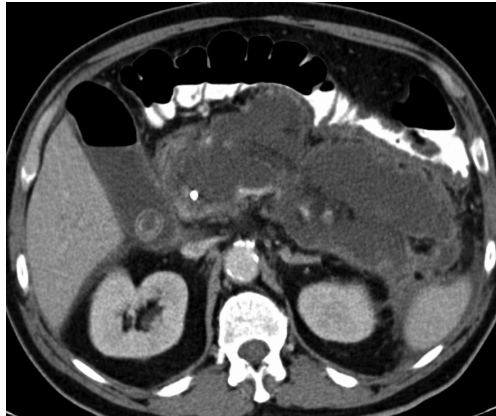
One of the 55 CT scans reviewed in this interobserver agreement study. The vast majority of reviewers described this CT as >50 pancreatic nonenhancement, with an intrapancreatic and adjacent collection which is encapsulated (either partially or completely), heterogeneous, with mass effect, an irregular shape, and without loculated gas bubbles or an air fluid level.
